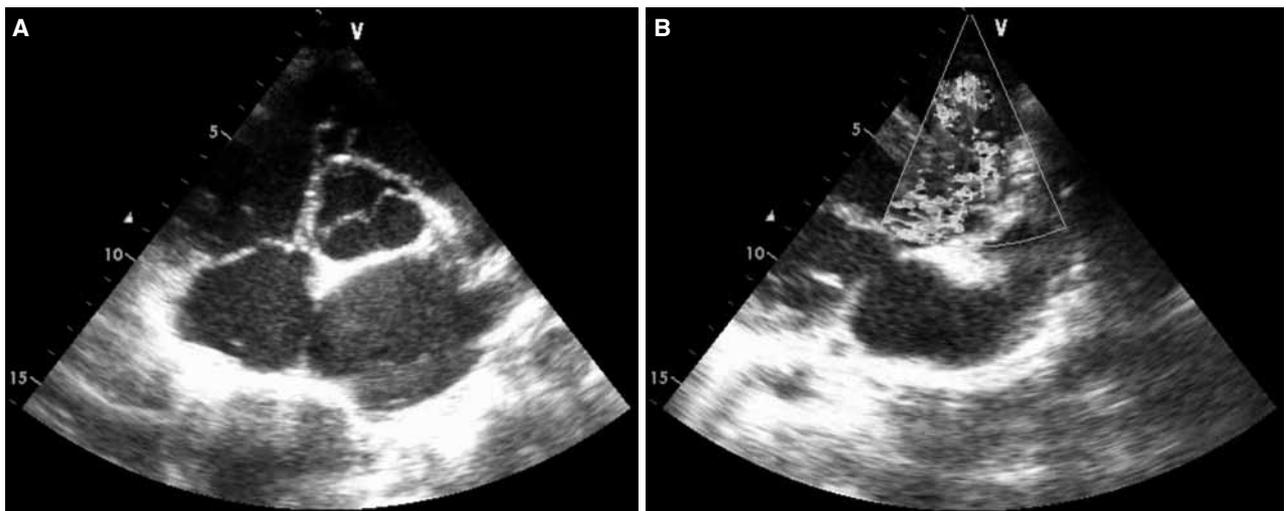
(A) Echocardiogram showing the windssock appearance. (B) Doppler-flow demonstration of rupture of the sinus of Valsalva aneurysm into the right ventricle.
